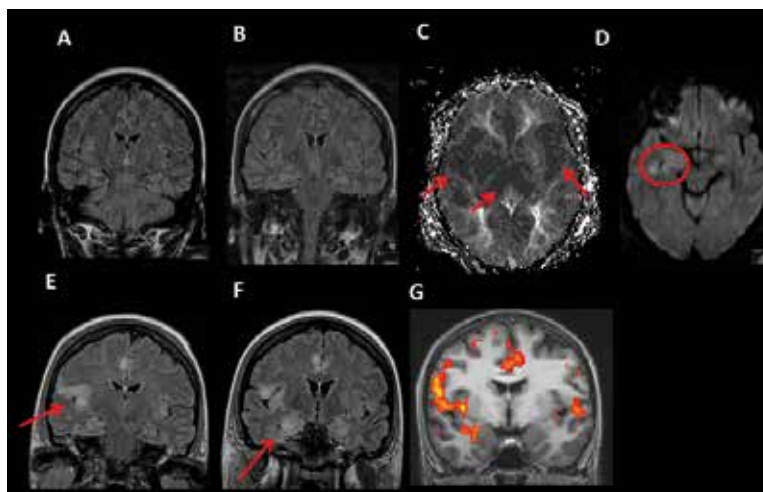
43 year old female, recurrent secondary generalized seizures for 2 days of unknown etiology, previously influenza symptomatology, at admission convulsive drug resistant status epilepticus, waxing and waning evolution with right hemispheric dominance of epileptic activity on EEG. A-D MRI at admission, unspecific white matter lesions, right dominant diffuse hyperperfusion (TTP), DWI restriction right hippocampus, E-F follow-up MRI: increasing gliosis/vasogenic edema bilateral in the hippocampus, the insula, fronto-basal and cingulum on FLAIR images, G- interictal hemodynamic correlates of MTLE (data from [11]). The distribution of the gliotic changes in drug resistant SE (no etiology of epilepsy disclosed on autopsy) and the interictal hemodynamic changes in MTLE are closely related, endorsing the notion that interictal epileptic activity involves identical neuronal networks as seizure activity.
